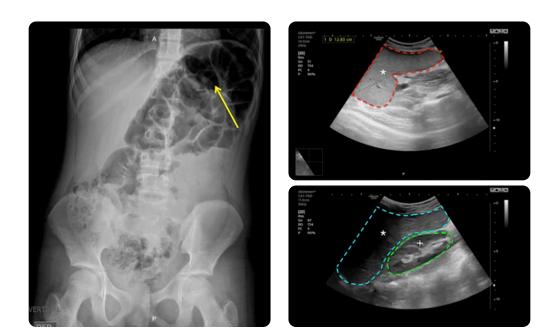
a) AP abdominal X-ray: left Chilaiditi sign associated with distension of colonic loops and small intestine, the splenic and renal silhouette cannot be identified. b) Initial ultrasound, splenic silhouette (*), the kidney is not observed due to its superior location. c) Second ultrasound performed 5 days later with 6 hours of symptoms, the spleen is observed (*), note the conventional location of the kidney (+), it is evident the lower echogenicity of the spleen in this image when compared with the previous one.
